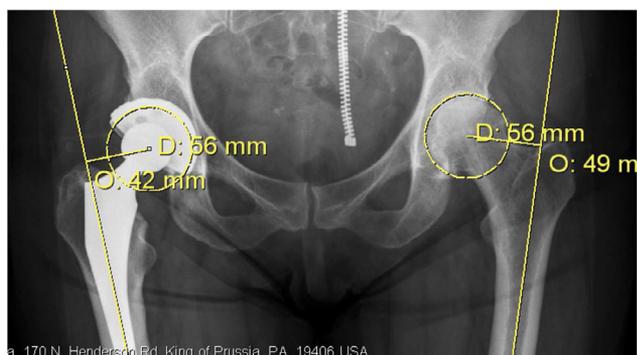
Demonstrates the pelvic radiograph of a patient indicated for revision for instability. In the index procedure, the patients native femoral offset was not restored, resulting in excessive soft tissue laxity. The patient underwent a successful femoral revision to a high-offset implant.
